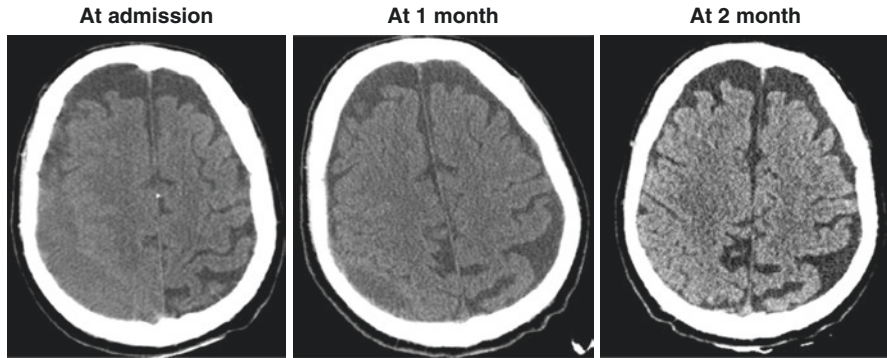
Serial CT scan showing the progressive resorption of CSDH in a 73-year-old man, who experienced hemiparesis and headache and memory disturbance 3 weeks after a benign head trauma, treated with atorvastatin for 8 weeks
